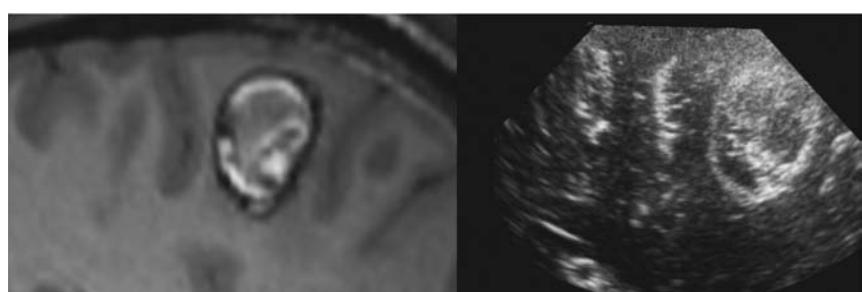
Registration of intraoperative ultrasound with pre-operative MRI.
